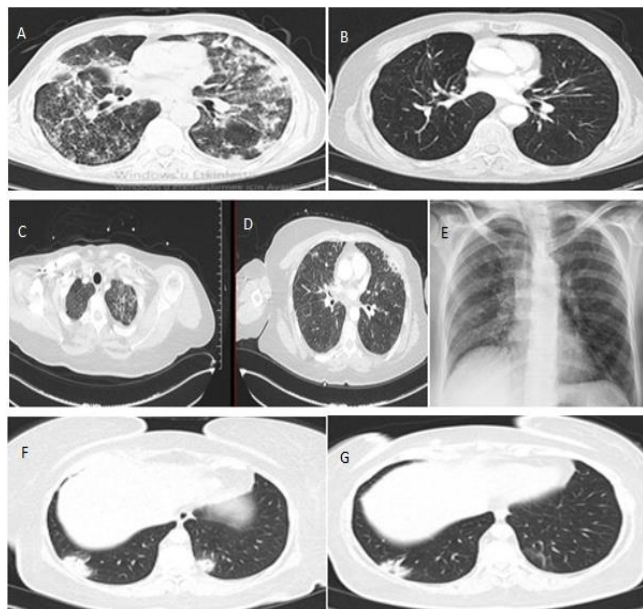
Diagnostic and follow-up thoracic CT slices of cases 4, 5, and 6. (A) Case 4 Thoracic CT at diagnosis, (B) Case 4 Thoracic CT two years after treatment, (C and D) Case 5 Thoracic CT at diagnosis, (E) Case 5 Posteroanterior chest X-ray two months after treatment, (F) Case 6 Thoracic CT at diagnosis, (G) Case 6 Thoracic CT two months after treatment.
